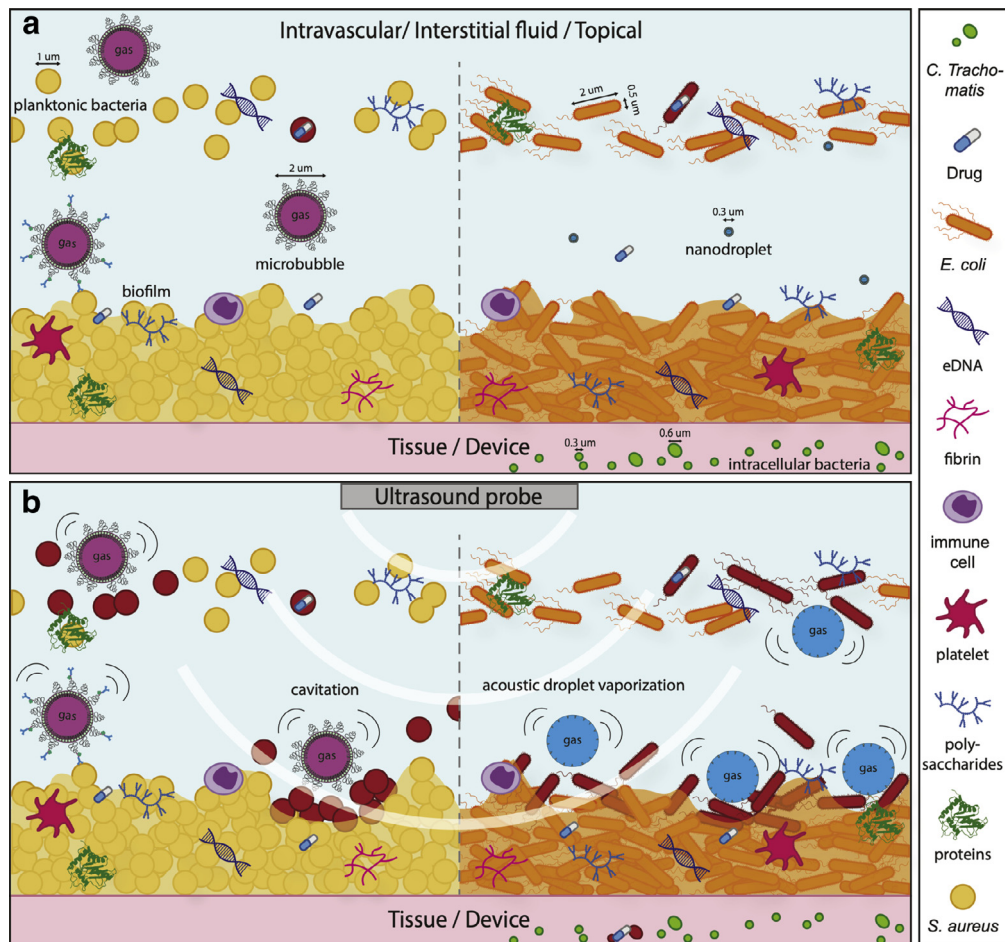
Concept of sonobactericide (not drawn to scale). (a) Potential infection environments before ultrasound. Sizing of bacteria and cavitation nuclei is denoted with a *double-headed arrow*. (b) Ultrasound application in which cavitating microbubbles and activated nanodroplets disrupt bacteria and biofilm composition. Bacteria that have become red in (b) are considered dead or to have compromised membranes because of the effects from ultrasound and cavitating nuclei.
